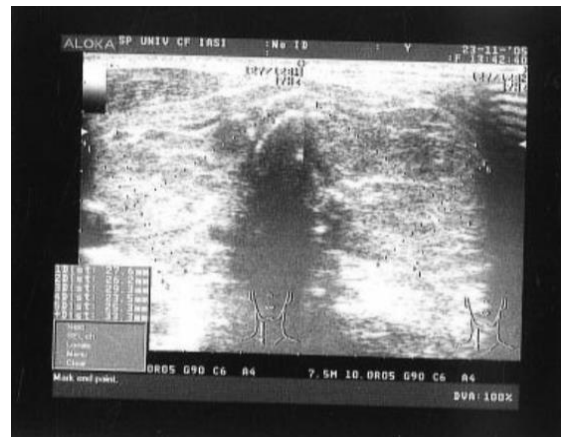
Preoperative ultrasonography of our patient
